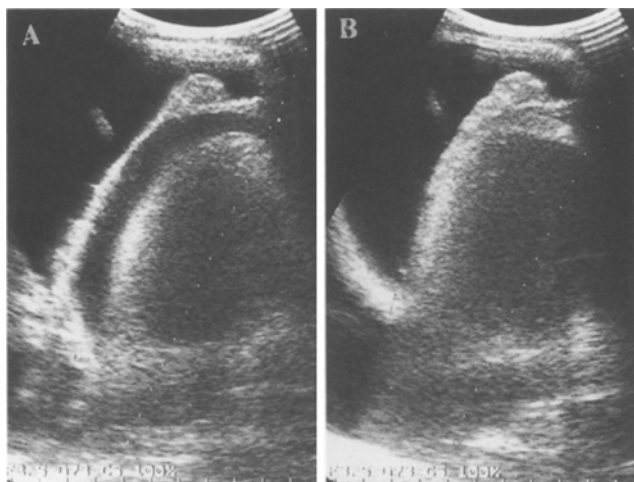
Echocardiography, A before treatment, showing a moderate amount of pericardiac effusion; B after treatment, revealing diminution of the pericardiac effusion
